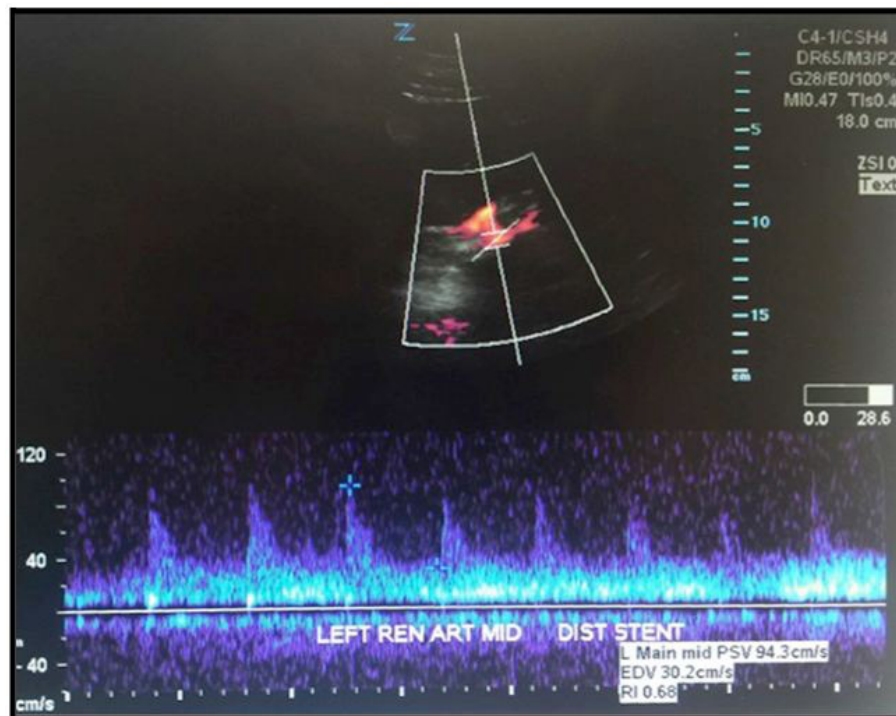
2 month follow up duplex ultrasonography status post stent graft repair
